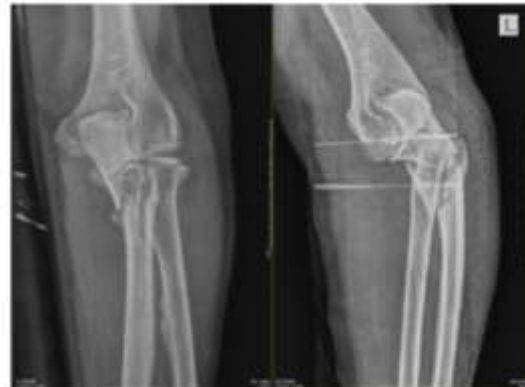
AP-Lateral Elbow X-ray
